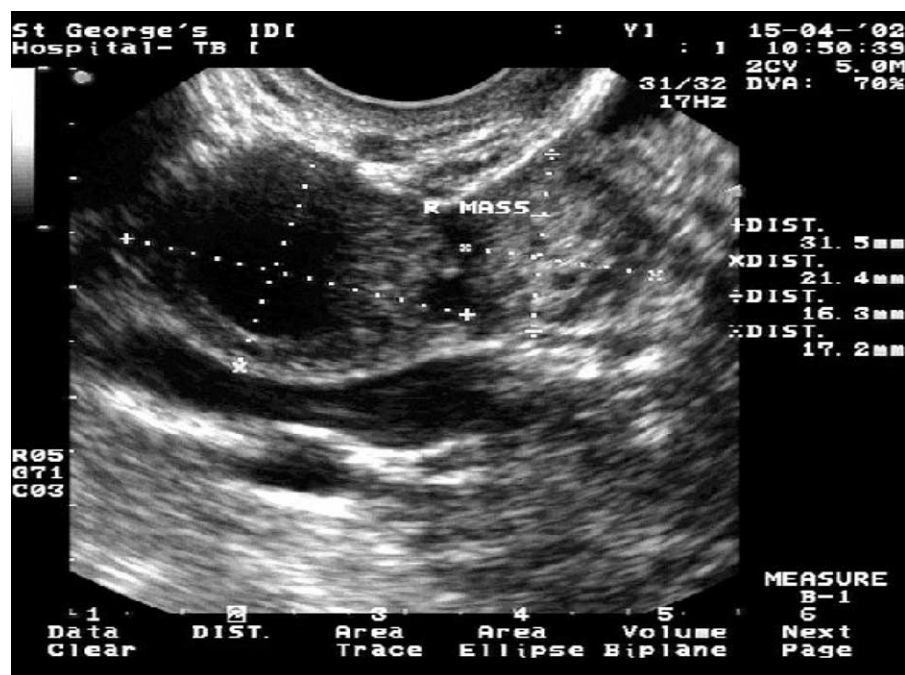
Inhomogeneous or inconglomerate mass adjacent to the right ovary. Reproduced with permission from: Condous et al. *Ultrasound Obstet Gynecol* 2003; 22; 420–430.
